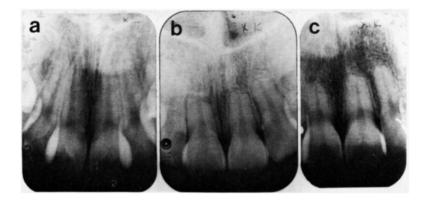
Radiographs of severely resorbed maxillary incisors during orthodontic treatment. a, Before treatment. b, After treatment. c, Posttreatment at 15.3 years. Note remodeling of sharp edges.
